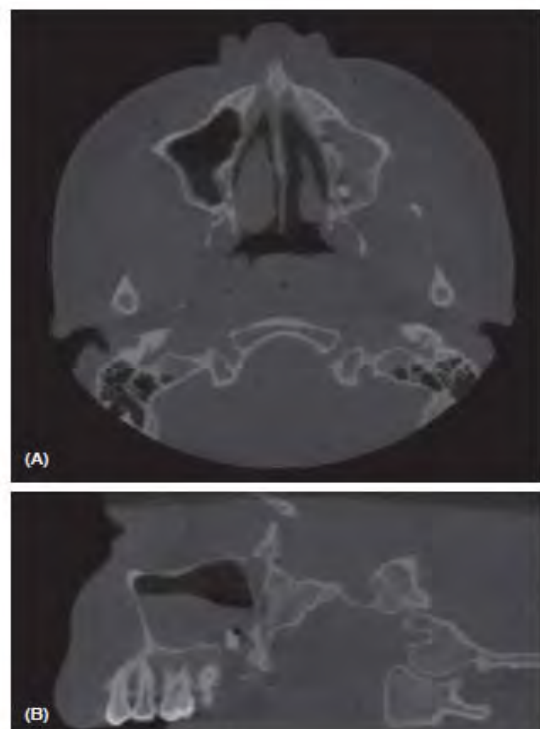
(A) Axial and (B) sagittal cone beam computed tomography images showing the loss of the corticated floor of the maxillary antrum in the left first molar region and the exact position of the two roots within the left maxillary antrum.
